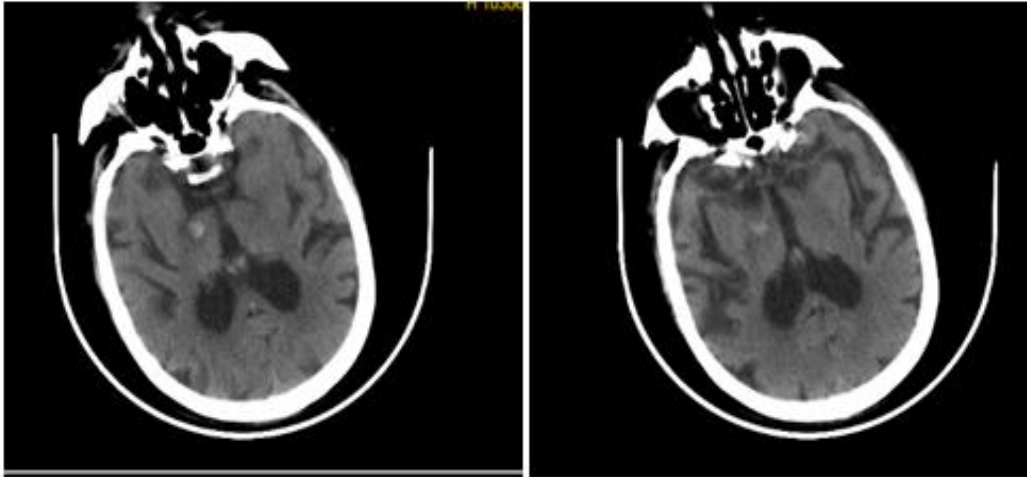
Axial unenhanced CT shows focal hemorrhage in the right sub thalamic nucleus
